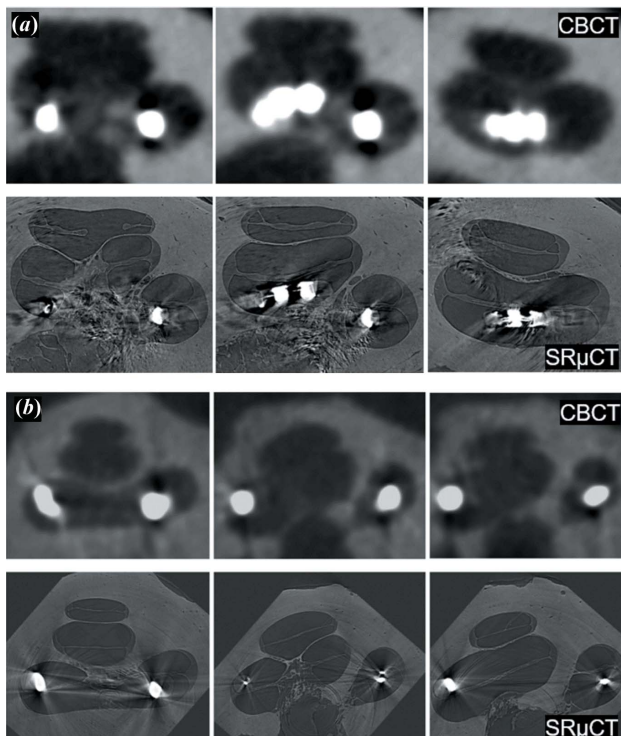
Two implanted cochleae visualized with clinical cone-beam computed tomography (CBCT) and synchrotron radiation computed microtomography ($\text{SR}\mu\text{CT}$). The images were rigidly co-registered with image-processing software to accurately align the volumetric datasets. (a) Atraumatic insertion into the scala tympani (the inferior partition of the cochlear duct), (b) traumatic electrode array dislocation into the scala vestibuli (the superior partition). Though clinical CBCT was unable to, $\text{SR}\mu\text{CT}$ could clearly reveal the separation between the cochlear scalae, thus confirming the scalar electrode location.
